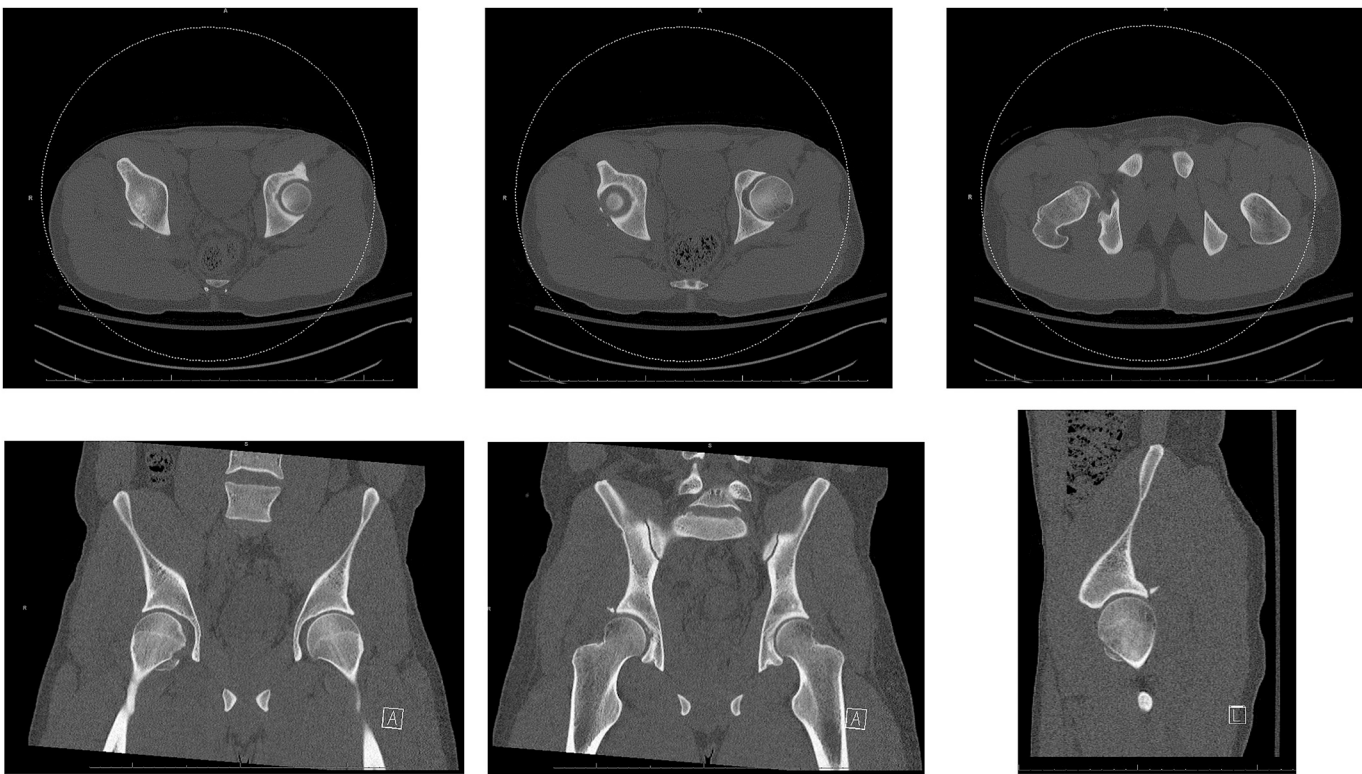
Axial, coronal and lateral select CT cuts of the pelvis post right hip reduction.
